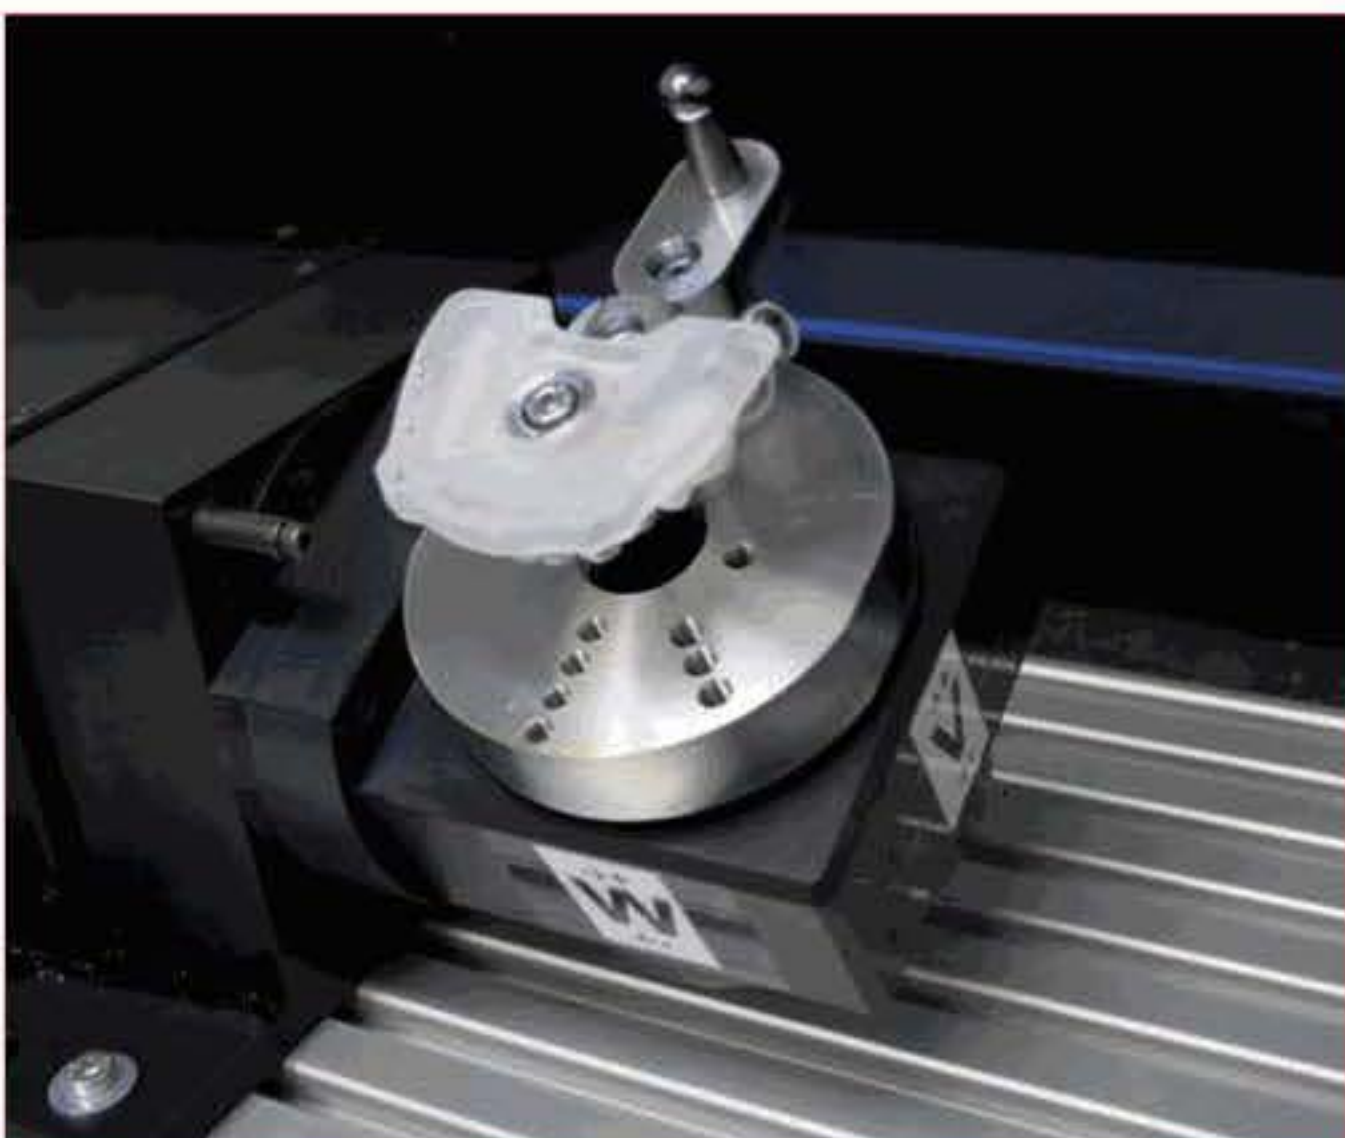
In the creation of the drilling template of the GALILEOS system, the x-ray template is first inserted into the computer-controlled five-axis milling machine. After detecting the registration markers, the mill carries out the drilling in accordance with the plan created in GALILEOS-Implant.
